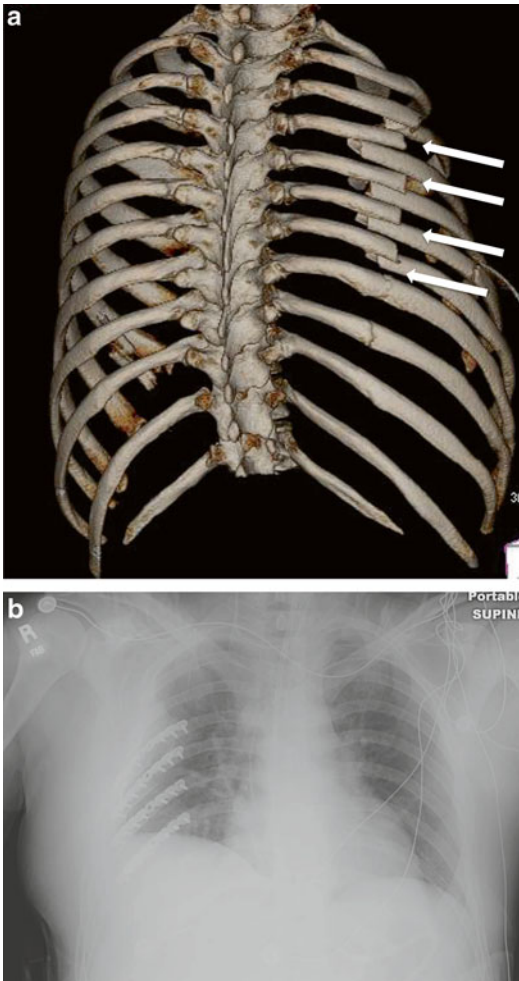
(a) Multiple adjacent right posterior rib fractures with shortening and displacement resulting in an unstable chest wall injury. Modern imaging techniques, such as the use of 3D reconstructions of standard CT scans, greatly facilitate the surgeon's overall comprehension of the injury pattern, fracture location, and potential surgical approaches. (b) This patient had primary open reduction and internal fixation of the flail segment through a posterior approach (see Chap. 8) with an excellent clinical outcome. However, current National Trauma Databank information suggests that less than 1 % of trauma patients with this type of flail chest injury are treated in this fashion (case courtesy of W. Drew Fielder, MD, FACS)
